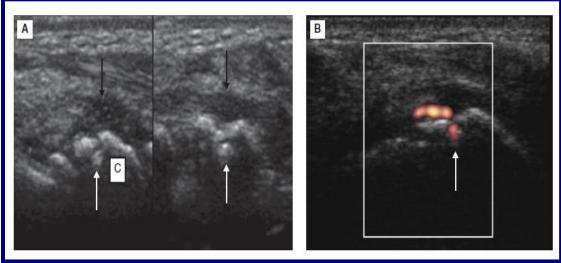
A Longitudinal and transverse image of radio-carpal joints showing hypoechoic synovial hypertrophy (black arrows) overlying the erosions (white arrows) seen as cortical defects. B Longitudinal image showing erosion with supplying vascular pedicle on power Doppler (white arrow). (6)
